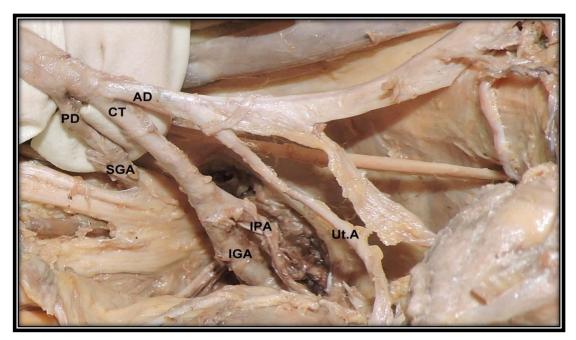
Left pelvic half shows trifurcation of internal iliac artery (IIA) into Posterior division (PD), Common Trunk (CT) of inferior gluteal artery (IGA) & internal pudendal artery (IPA) and Anterior division (AD). Ut.A: Uterine Artery.
